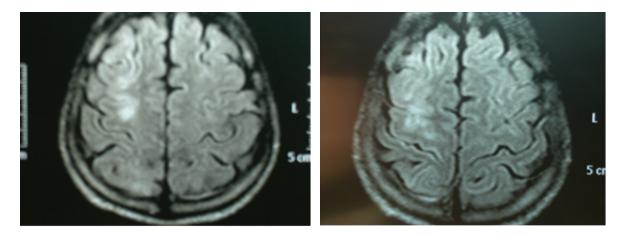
Axial MRI FLAIR image taken 20 h from the onset symptoms showed a gyriform signal increase in the right cerebral hemisphere.
